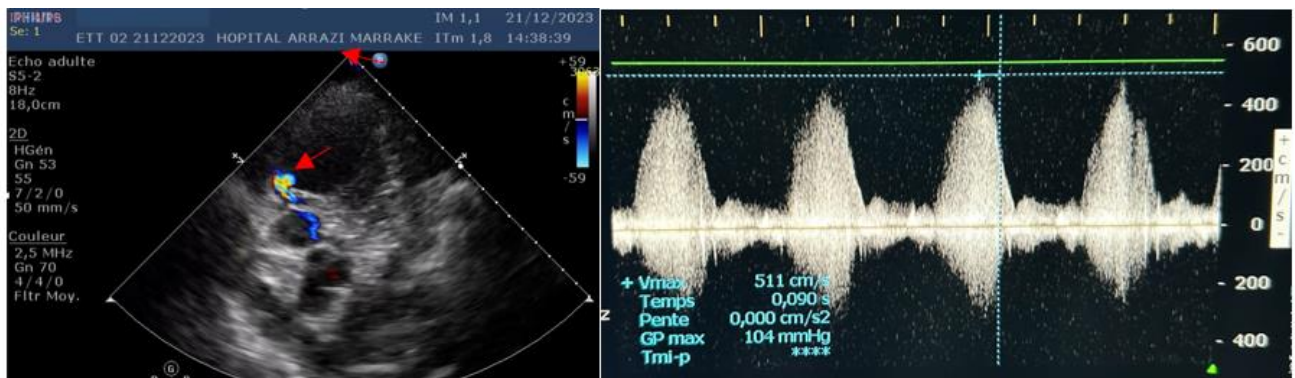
This 66-year-old patient was admitted with STEMI anteriorly. Echocardiography showed segmental hypokinetic heart disease with severe LV dysfunction (30-35%), the site of an apical aneurysm, associated with a 7 mm apical muscular IVC image responsible for a left-right shunt.
